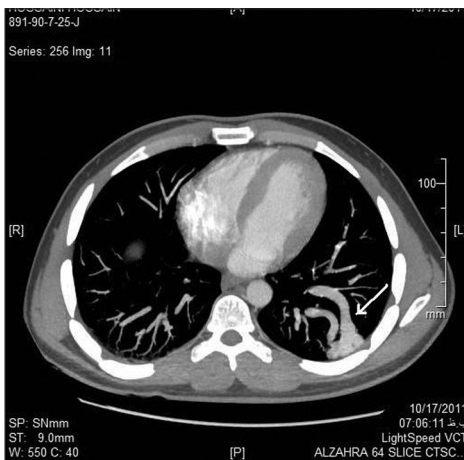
Thoracic CT reveals AVM of left lower lobe (arrow)
